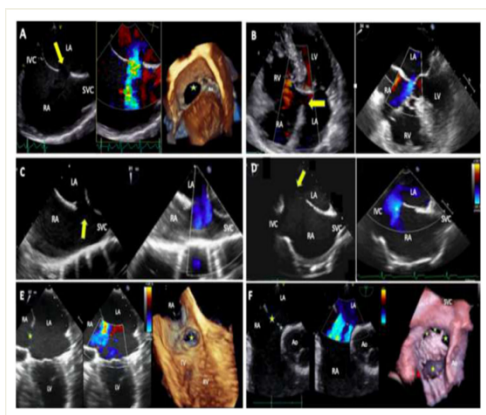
Echocardiography image of atrial septal defect
